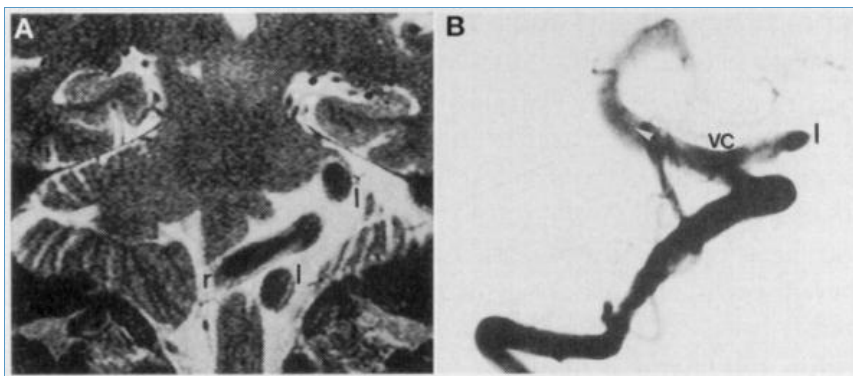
A, T2-weighted magnetic resonance image in the coronal plane, demonstrating the right megadolichovertebral artery transverse and compressing the medulla oblongata (r). Note the two sections through the left megaverterbral artery (l). B, angiogram, left oblique view, after contrast injection into the right megadolichovertebral artery. Note the contrast filling of the vertebral conjunction (vc), some retrograde flow in the distal portion of the left vertebral artery (l), and contrast filling of the megadolichobasilar artery (white arrowhead), which is crossing over the pons back to the right side.
